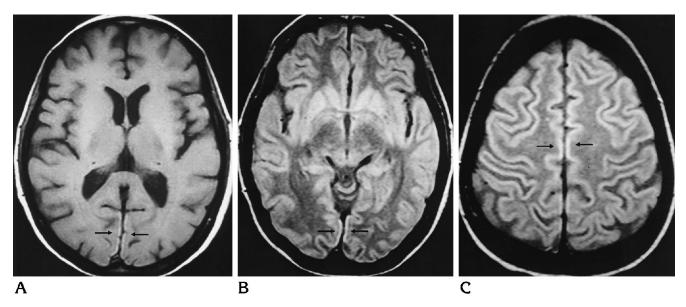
Patient 4: 49-year-old woman with speech deceleration and cortical amaurosis 24 days after liver transplantation. A, T1-weighted image (640/20) shows laminar hyperintensity (arrows) in the occipital cortex bilaterally.
